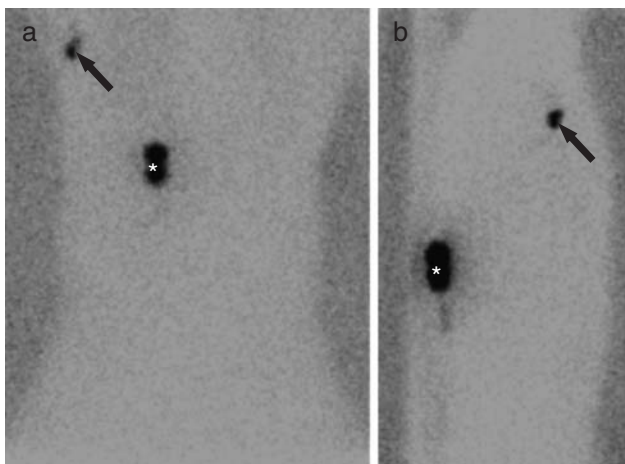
Lymphoscintigram, (a) anterior and (b) right lateral views, in a 30-year-old patient with melanoma of the trunk. The arrows depict a sentinel lymph node in the right axilla as confirmed by surgical exploration. (*) Injection site.
